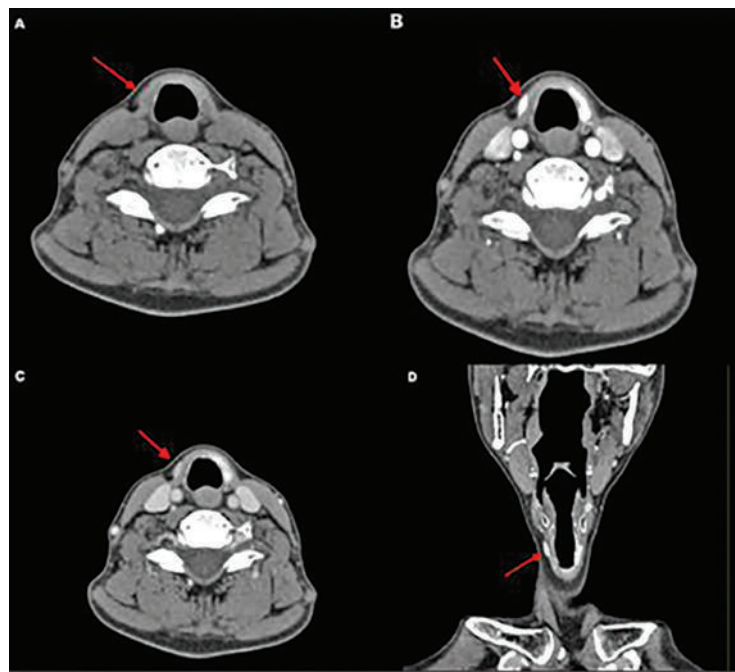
Four-dimensional contrast-enhanced CT imaging of the neck. (A) Non-contrast axial image shows an isodense fusiform lesion. (B) Axial arterial-phase images demonstrate a well-defined, avidly enhancing 7×5 mm lesion located anterior to the strap muscles. (C) The lesion exhibits a washout pattern on venous-phase images. (D) The arterial-phase coronal reconstructed image demonstrates an arterially hyperenhancing, tear-drop-shaped lesion located adjacent to the strap muscles, consistent with an autotransplanted parathyroid adenoma.
